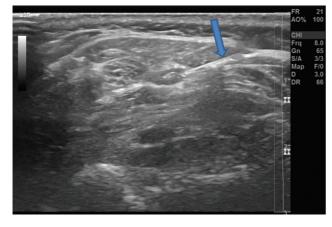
(Case 1)—Ultrasonography image of greater occipital nerve block via 10 mL syringe needle into the perineural sheath for a patient with c/o occipital neuralgia.
